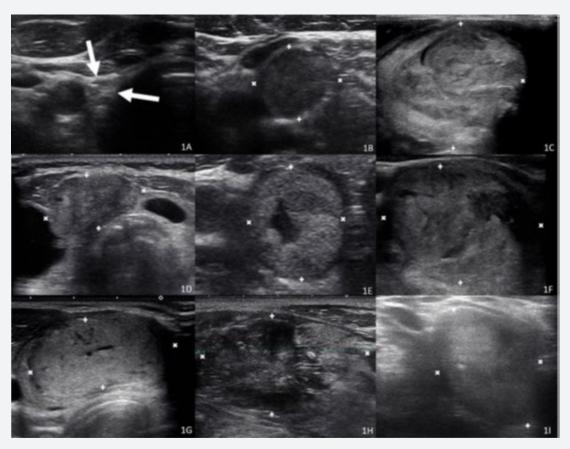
Thyroid ultrasound of cases with pathology confirmed malignancy or likely malignant by cytology and clinical course. Surgical pathology confirmed malignancy in case 1 (1A: right thyroid bed mass (arrows), 1B: left level IV 1.5 cm lymph node), case 2 (1C: 6.5 cm TR3 nodule), case 3 (1D: 1.7 cm TR4 nodule), case 4 (1E: 1.9 cm TR4 nodule), case 5 (1F: 4.6 cm TR4 nodule) and case 6 (1G: 3.8 cm TR3 nodule). Case 7 (1H: 4.8 cm TR5 nodule) had Bethesda VI from FNA. Case 10 (1I: >3.7 cm TR5 nodule) was likely malignant by clinical course and Bethesda V from FNA. All images are transverse views except for case 7 (1H), which is a longitudinal view.
